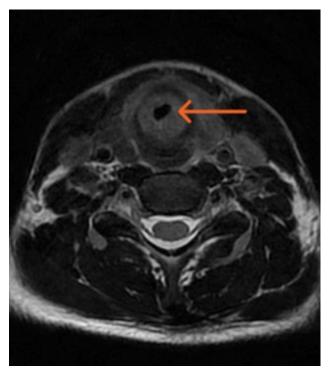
T2-weighted MRI image showing tracheal stenosis (arrow).
